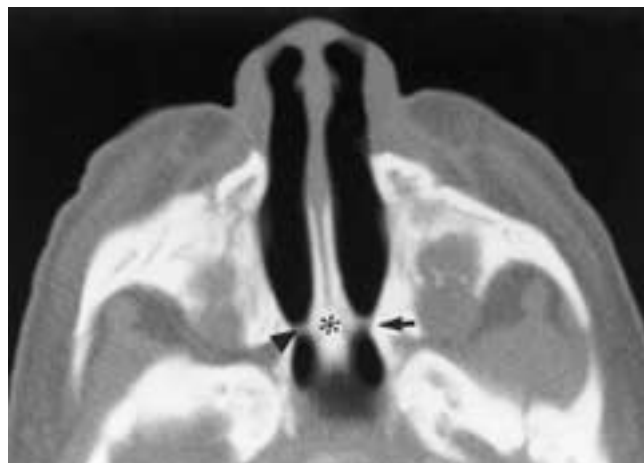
Bilateral membranous and bony choanal atresia in a 1-day-old girl. Axial CT scan obtained after suctioning the nasal cavity. There is thickening of the posterior vomer (*asterisk*). The posteromedial maxilla is bowed medially (*arrow*) and approximates the lateral margin of the vomer. There is a small membrane completing the atresia (*arrowhead*). Note the normal dimensions of the pyriform apertures anteriorly.
